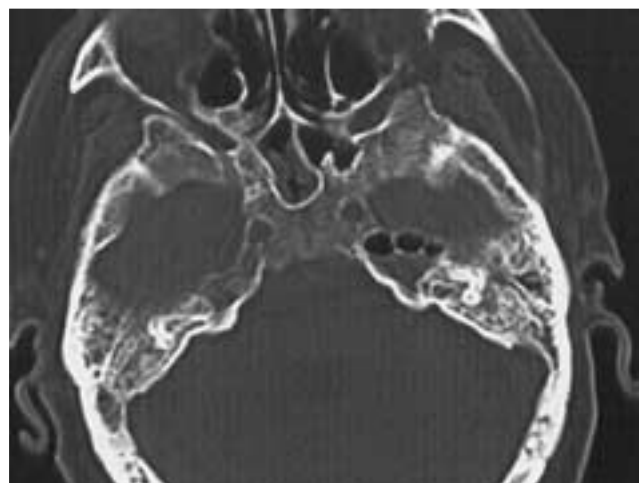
Petrous apex effusion. CT image shows bilateral mastoid fluid, with an air-fluid level in the left petrous apex and intact bony septa. Serous otitis was found at surgery, and petrous apex fluid was an incidental finding in an asymptomatic patient.
